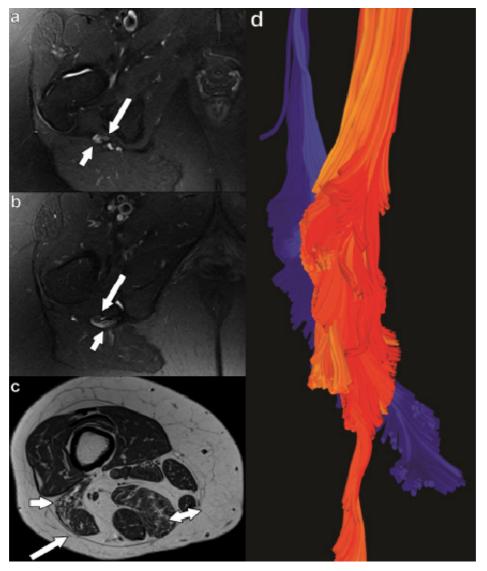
MR neurography and DTI study of the right thigh. (a) Axial T2-weighted fat suppressed image demonstrates abnormal separation of the tibial and peroneal components of the proximal sciatic nerve (long arrow, tibial nerve; short arrow, peroneal nerve). (b) The peroneal nerve is edematous and appears to terminate at the ischial tuberosity (short arrow, peroneal nerve; long arrow, tibial nerve). (c) Axial T1-weighted image through the mid thigh demonstrates fatty atrophy of both tibial and peroneal supplied muscles (short arrow, biceps femoris short head; long arrow, biceps femoris long head; double arrow, semitendinosus). (d) Tractography demonstrates no trackable peroneal fibers after it terminates in the region of the ischial tuberosity (blue, peroneal nerve; red, tibial nerve).
